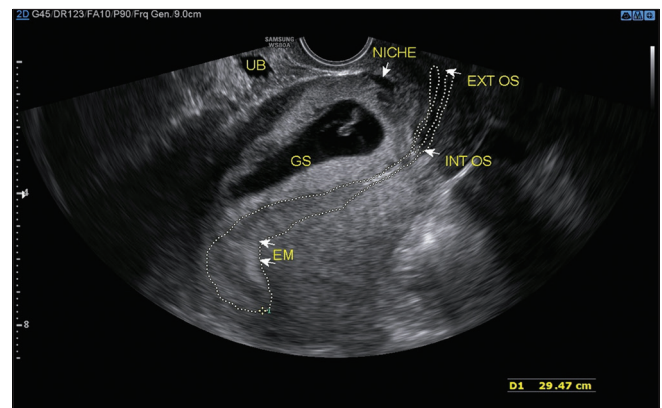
Transvaginal ultrasound image showing the gestational sac, niche, endometrium, internal os, external os, and urinary bladder as labeled
